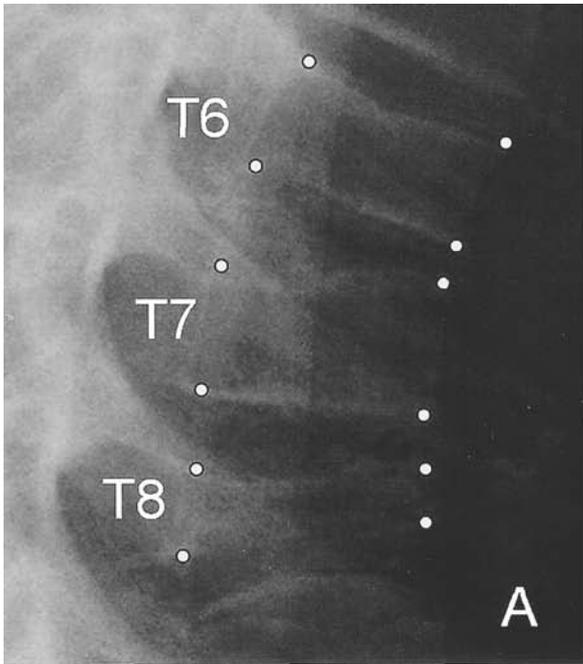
Lateral spinal radiographs of T6–T8 in Patient 1 show improvement in vertebral morphometry from start of pamidronate therapy (A) and at last followup 3 years later (B).
